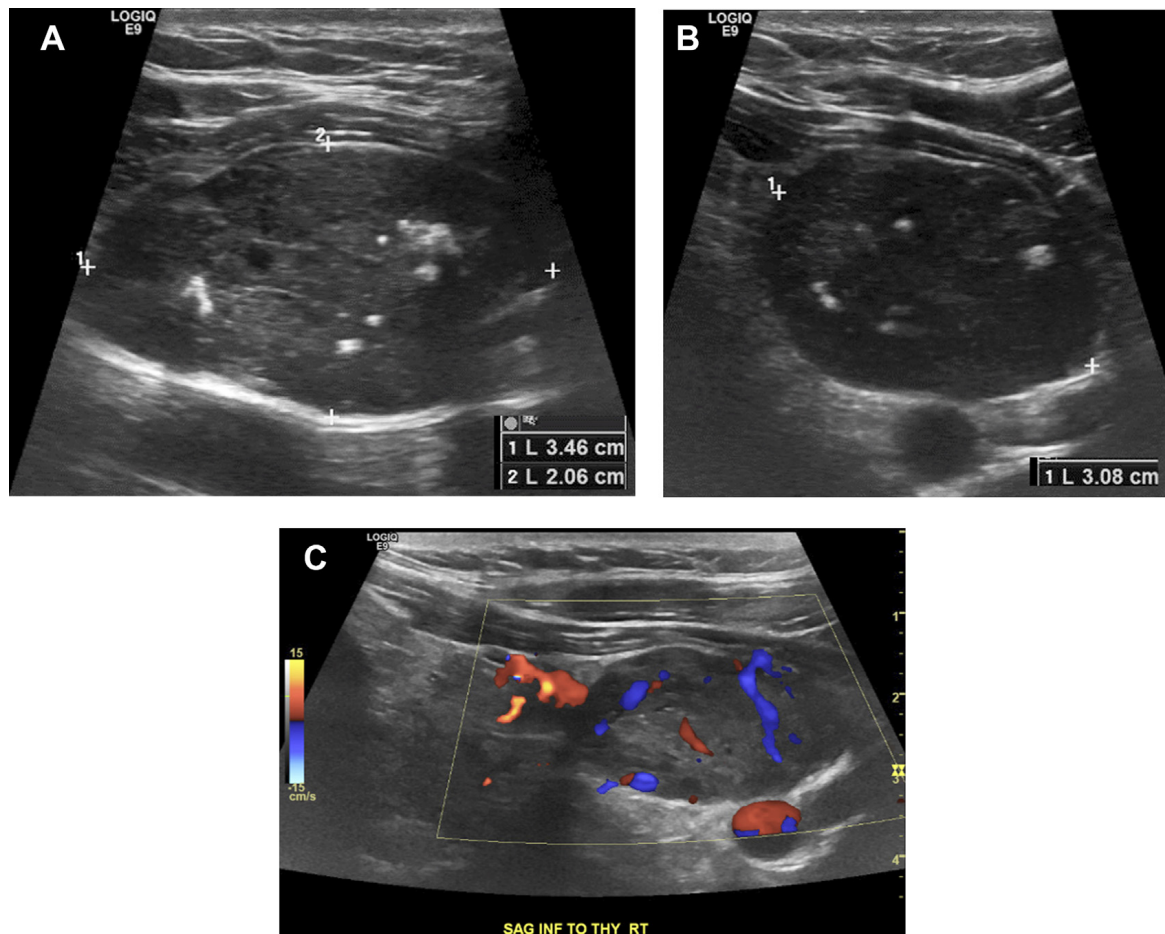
Parathyroid carcinoma. (A) Sagittal and (B) axial B-mode images and (C) axial color Doppler images in a 38-year-old man with primary hyperparathyroidism demonstrate an enlarged parathyroid with internal calcifications (*cursors* in A and B). Pathology was consistent with parathyroid carcinoma with negative surgical margins.
